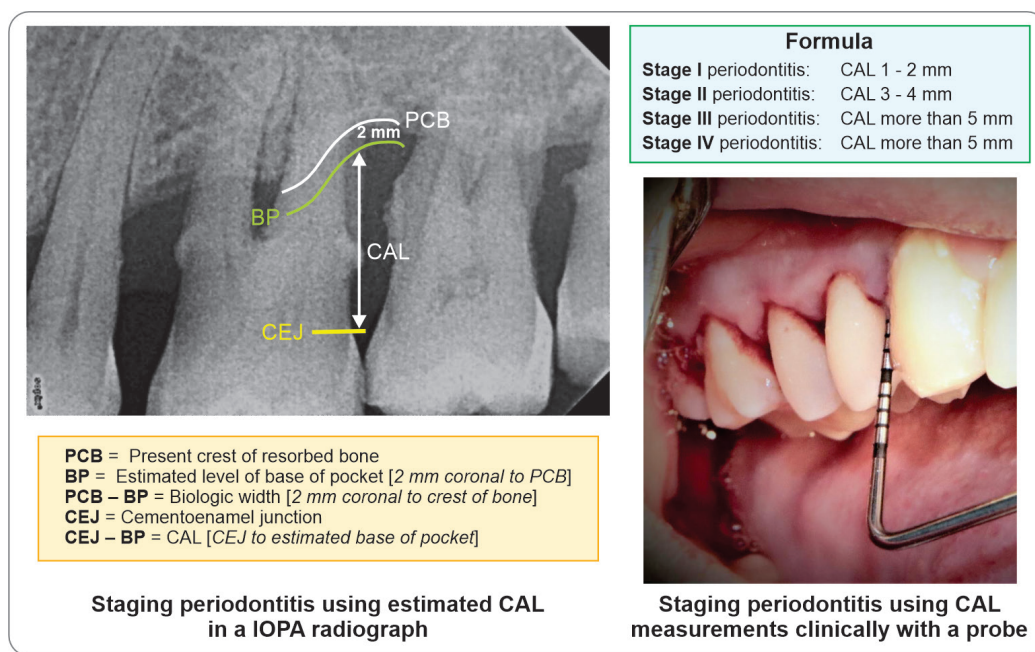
10: Measuring CAL clinically and radiographically to stage periodontitis.
